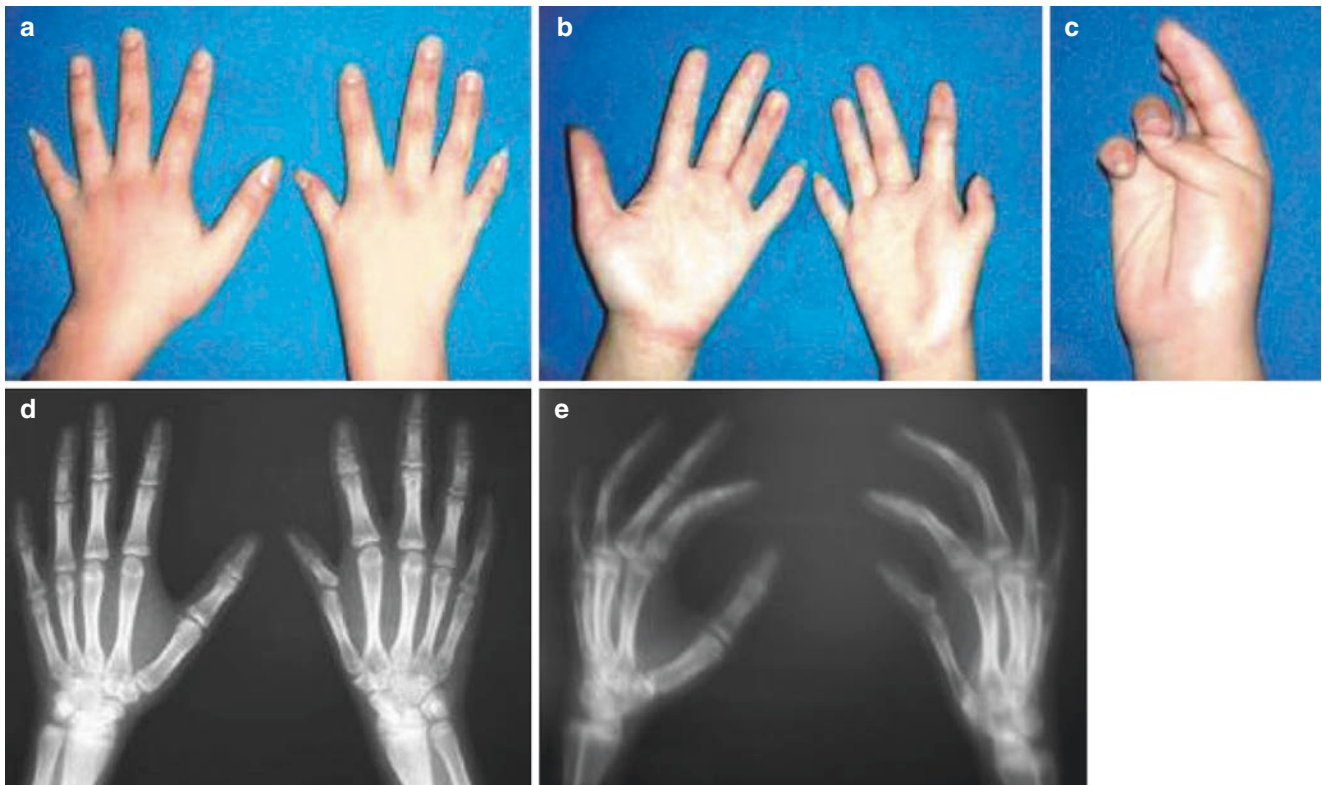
Case six: type IId thumb dysplasia of the right hand. (a–c) Appearance of the two hands. (d, e) X-ray findings
